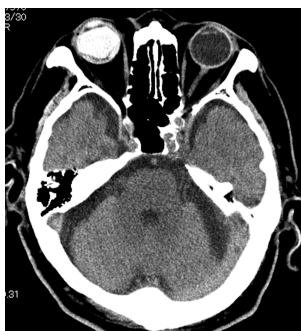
Brain computed tomography scan.
